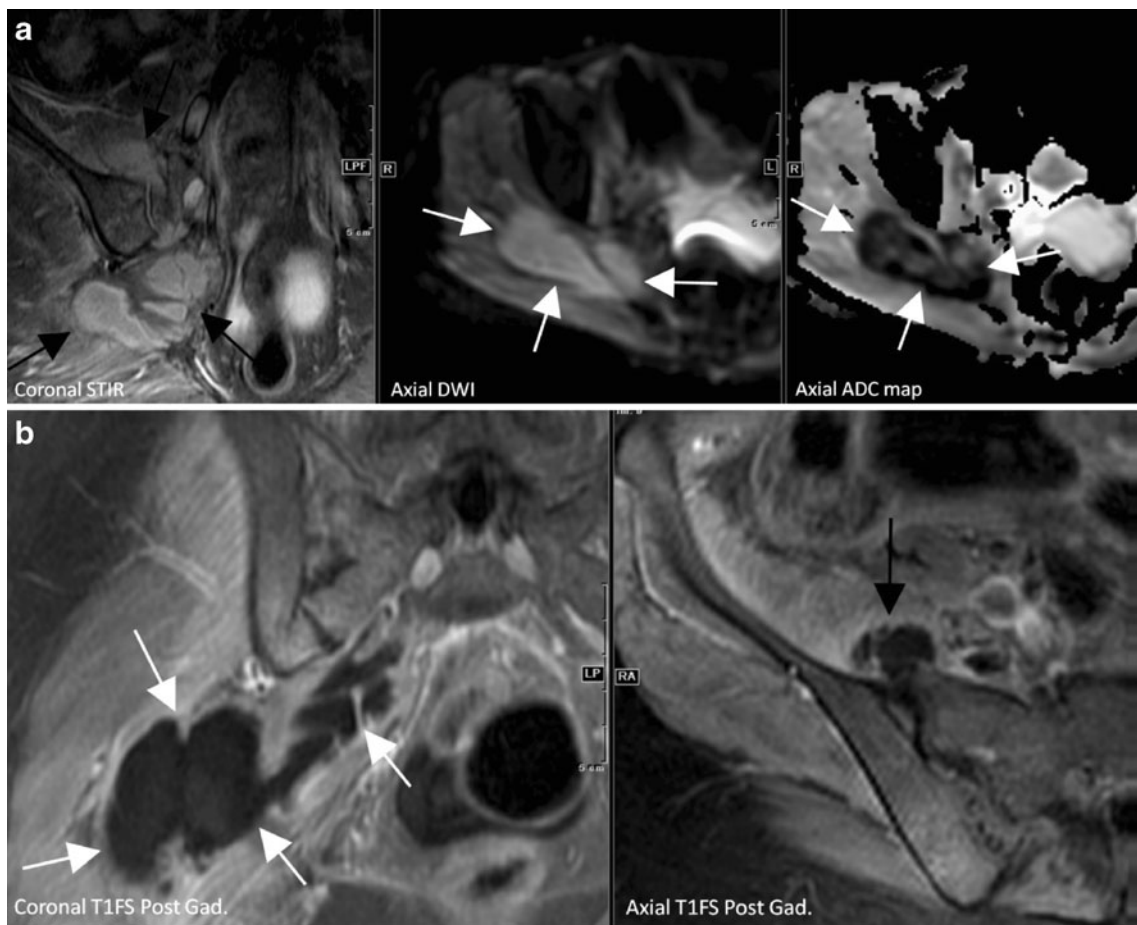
a (Case 6): Coronal STIR MR image showing large fluid collection (*black arrows*) emanating from the right SI joint and reaching the gluteal region through the sciatic notch. The fluid collection is DWI bright (*white arrows*) and ADC dark (*white arrows*)
